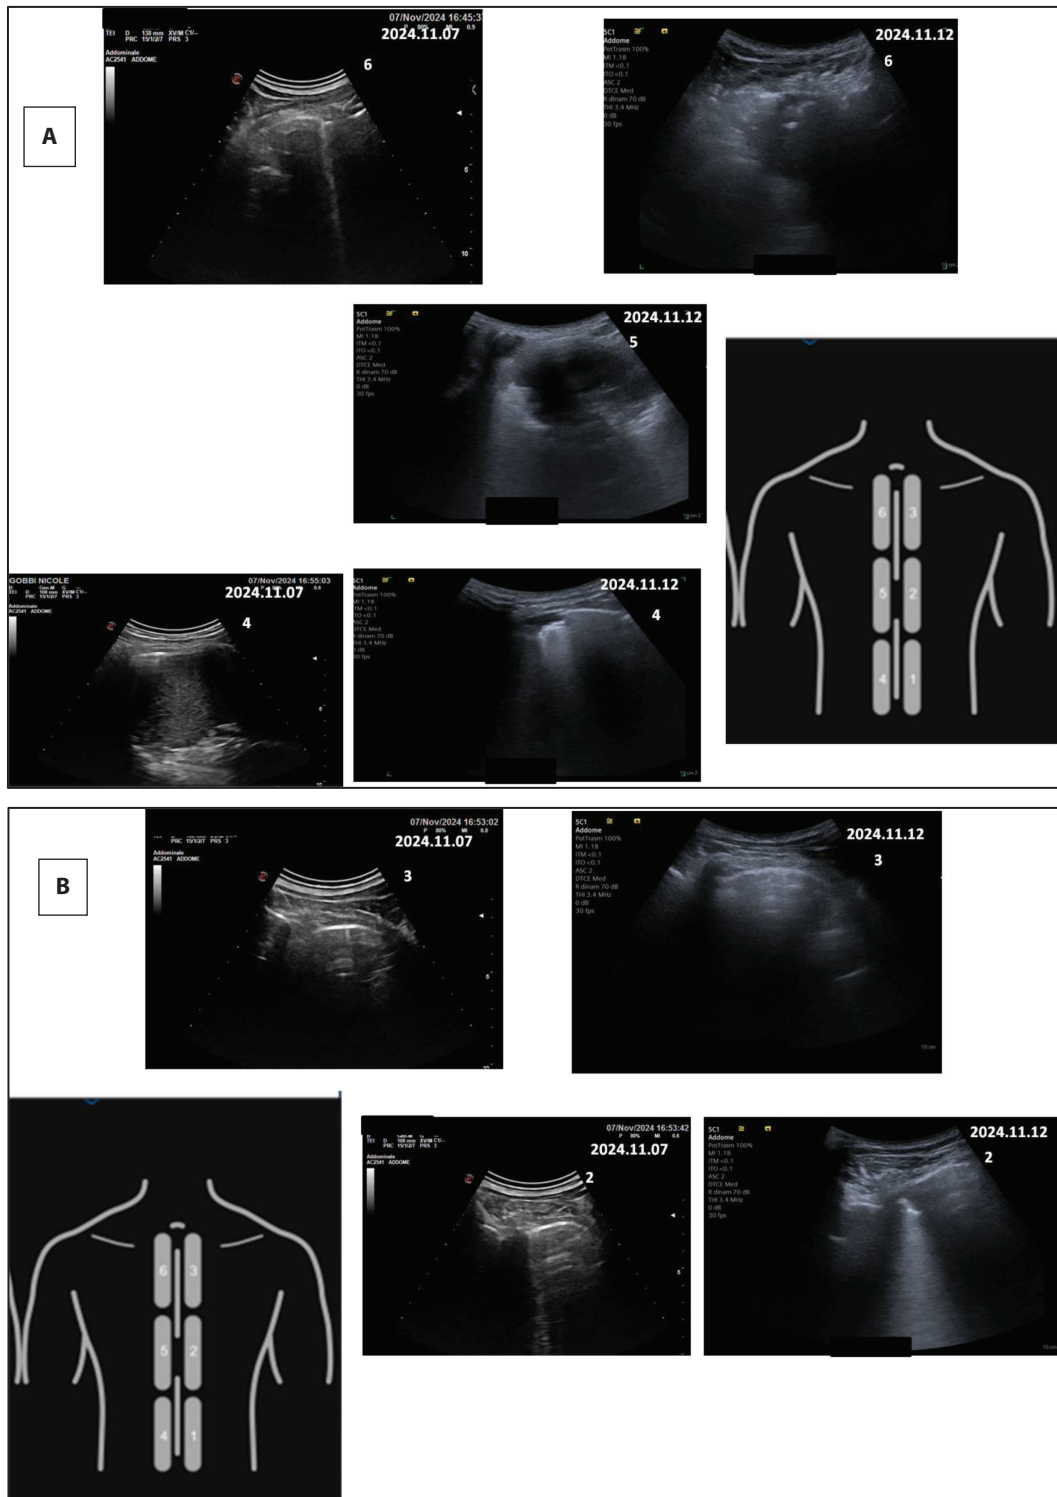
(A-D) LUS: Lung ultrasound images showing round hypoechoic consolidations (infiltrates) with hypoechoic pleura. Serial monitoring demonstrated progressive enlargement and increasing number of consolidations over three days.
